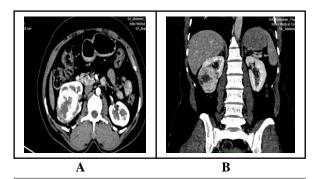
Case of renal cell carcinoma (Oncocytoma). Contrast enhanced computed tomography scan of 56-year-old female patient with sharply circumscribed mass in right kidney demonstrate avid contrast uptake with hypodense star shaped central scar. (A) Axial image (corticomedullary phase). (B) Reformatted coronal image (nephrogenic phase).
